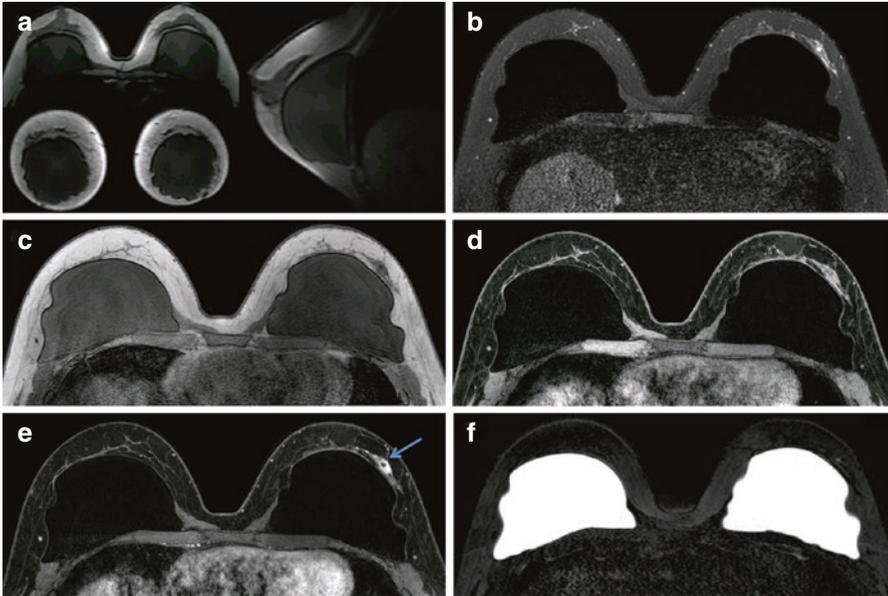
Key breast MRI pulse sequences. Thirty-nine year old woman presents for breast MRI to evaluate extent of disease for known invasive ductal carcinoma of the left breast (*arrow*). Basic sequences include three-plane localizer sequence (a), fluid-sensitive sequence (in this case, fast spin echo T2-weighted image with fat saturation) (b), non-fat suppressed T1-weighted sequence (c), multiphase dynamic contrast-enhanced T1-weighted series with representative pre-contrast (d) and first post-contrast (e) images presented. Note the enhancing mass (*arrow*), which represents the biopsy-proven invasive ductal carcinoma, with susceptibility artifact within, representing a biopsy marker clip. A silicone-weighted series (f) was also obtained in this woman with prepectoral silicone implants
